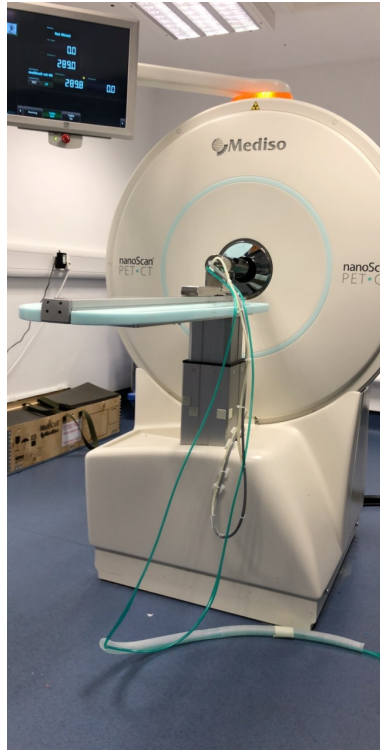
A picture of Mediso PET/CT nano scanner.
